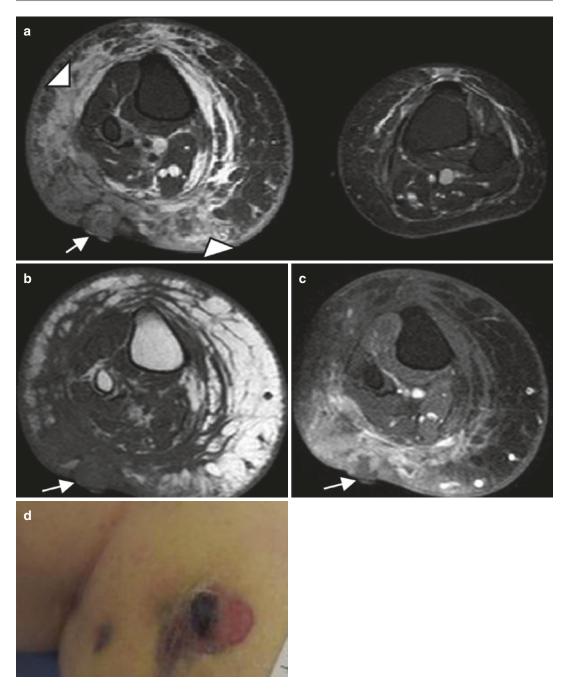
Stewart-Treves syndrome in a 66-year-old woman who was treated 20 years ago for uterus cervical cancer. (a) Axial T2-weighted MR image, with fat suppression. (b) Axial T1-weighted MR image after Gadolinium contrast administration, with fat suppression. (d) Clinical photograph. (a) Axial T2-W fat-suppressed MR images reveals an
